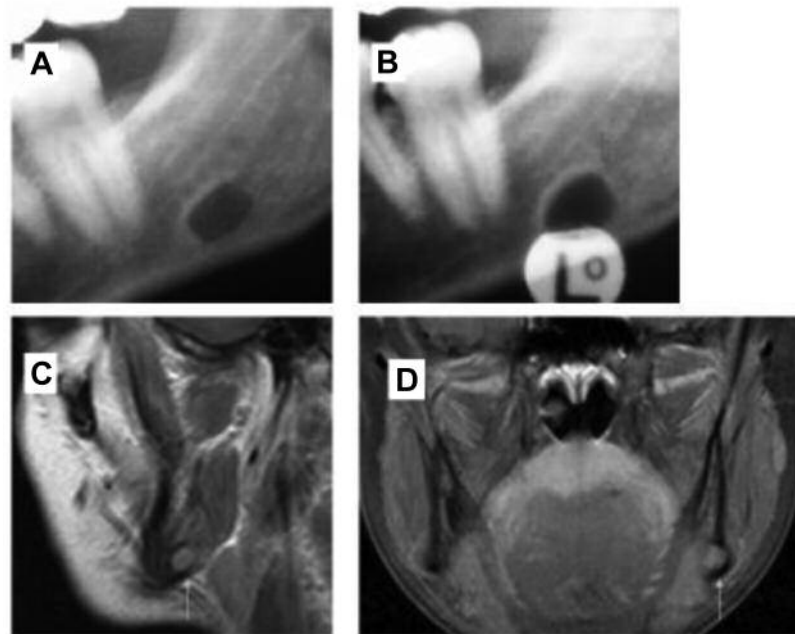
Stafne's bone cavity in a female patient with neurofibromatosis type 1. A. Panoramic view at the age of 29 years (cropped image). B. Panoramic view (cropped image) at the age of 34 when the patient was examined. The oval translucent lesion is located below the nerve canal, completely circumscribed by bone, and has the largest diameter in the anterior-distal direction. The two X-ray images show no change in findings. C. Magnetic resonance image (sagittal plane) of the patient's head showing a hyperintense, well-defined lesion in the dorsal part of the left side of mandible (arrow). D. Coronal view of this region depicts the hyperintense intraosseous lesion (arrow) in continuity with adjacent salivary gland.
